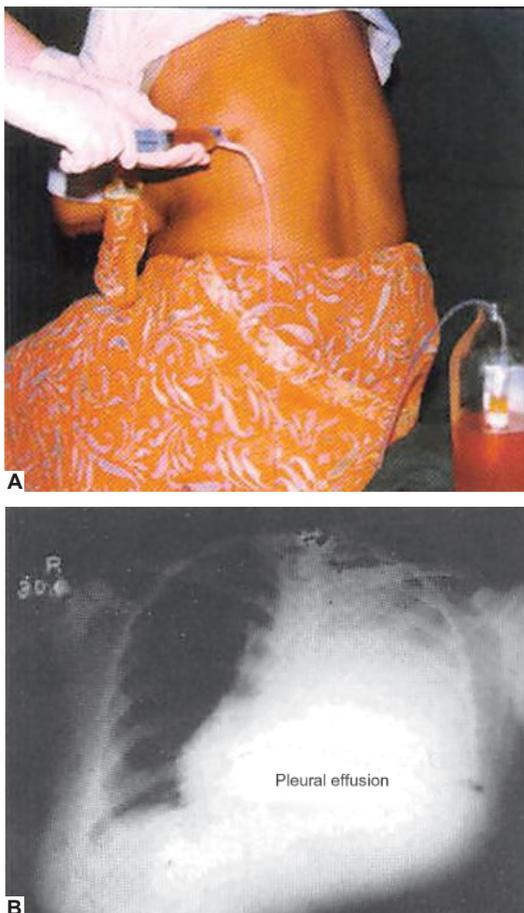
Pleural effusion left side: A. Fluid drainage; B. Chest X-ray
